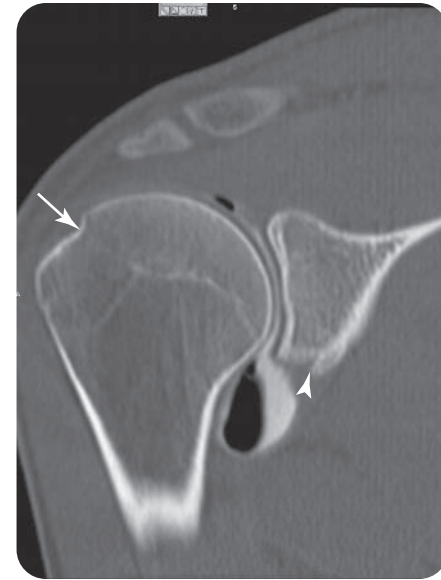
Selected coronal image from a right shoulder computed tomography arthrogram with iodinated contrast and air contrast demonstrating Hill-Sachs lesion (*arrow*) and Bankart fracture (*arrowhead*). This 23-year-old man dislocated his right shoulder 6 weeks earlier when he fell off the back of a moving truck.
